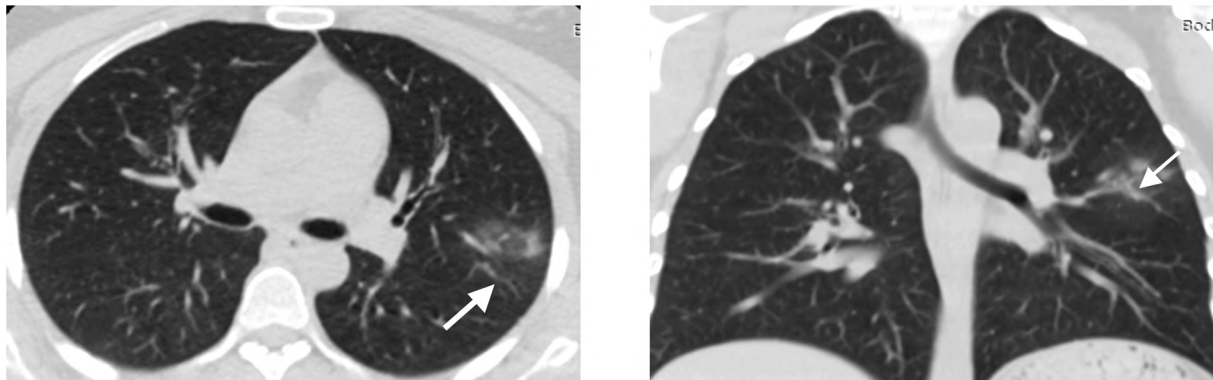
Non contrast axial and coronal CT chest images in 27 year sold woman imaged 4 days from symptoms onset (early phase), shows unifocal left upper lung lobe GGO (arrow), CO-RADS 3.
